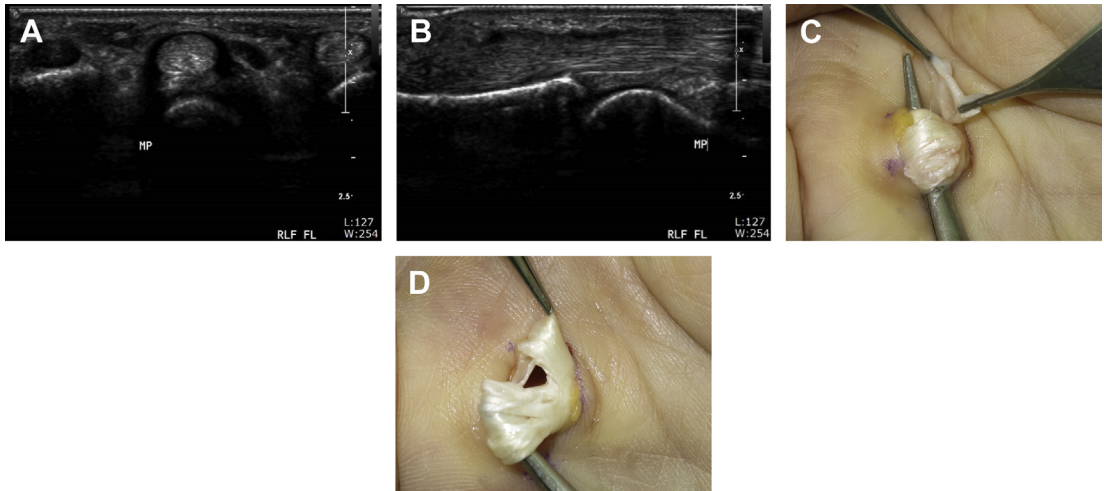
(A, B) Axial and longitudinal ultrasonography images show mild hypoechoic thickening of the A1 pulley with minimal peritendinous fluid along the flexor tendon. (C, D) Beginner golfer: a 45-year-old man practiced 7 days a week at a driving range for 3 months. He hit more than 200 balls every day. On the A1 pulley release of the right long finger, the flexor tendon ruptured longitudinally and tenosynovium was hypertrophied.
